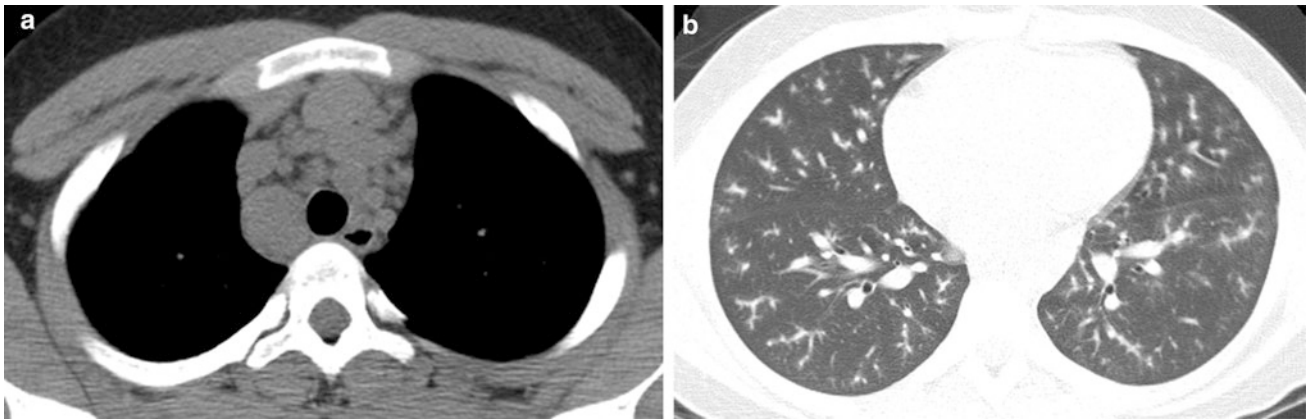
Sarcoidosis. An axial chest CT image reconstructed in soft tissue windows (a) from a 13-year-old boy with sarcoidosis demonstrates mediastinal lymphadenopathy (a). An axial chest image
